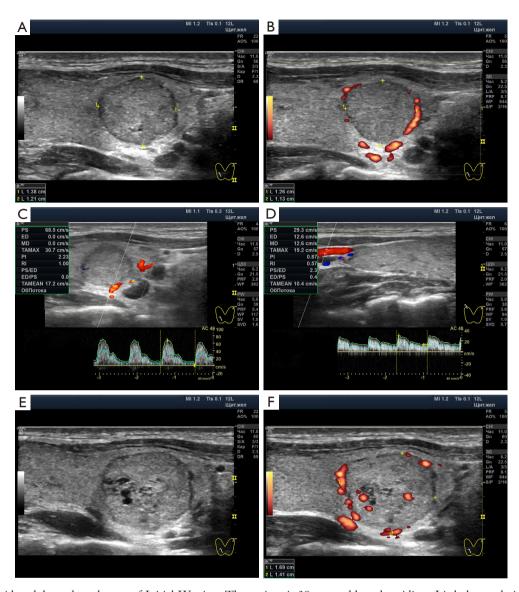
Thyroid nodule at the substage of Initial Wasting. The patient is 39 years old, euthyroidism. Little hypoechoic tissue is visible in the nodule. Single small anechoic areas are noticeable. Hyperechogenicity is determined dorsal to the nodule. (A,B) In January 2019, the size of the nodule in the longitudinal projection is 13.8×12.1 mm. In the power Doppler mode, low active blood flow of the nodule is determined. (C,D) In January 2019, the nodule artery had a peak systolic velocity of 68 cm/s, and the superior thyroid artery had a peak systolic velocity of 29.3 cm/s. (E,F) In October 2020, the size of the nodule in the longitudinal projection is 16.2×13.3 mm. The blood flow of the nodule is poorly expressed.
